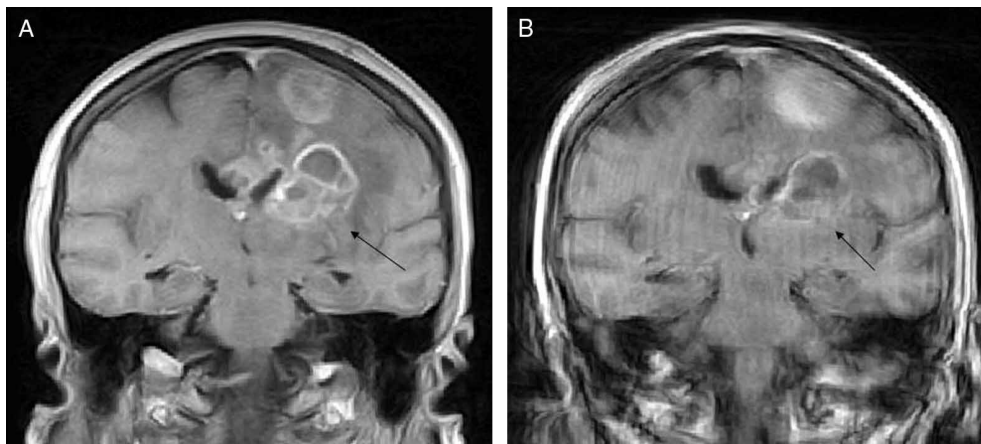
MRI coronal reconstruction of T1-weighted contrast-enhanced images at similar rostro-caudal levels. (A) Two days before posaconazole treatment initiation. Note seeding along biopsy tract. (B) Eleven days after posaconazole treatment the enhancement of the lesions were reduced.
